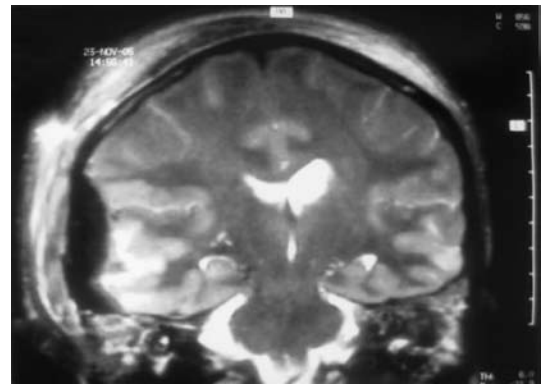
T2-weighted MRI image of the brain showing left temporal hemorrhagic contusion and adjacent extradural hemorrhage, and contralateral contre-coup contusion.
